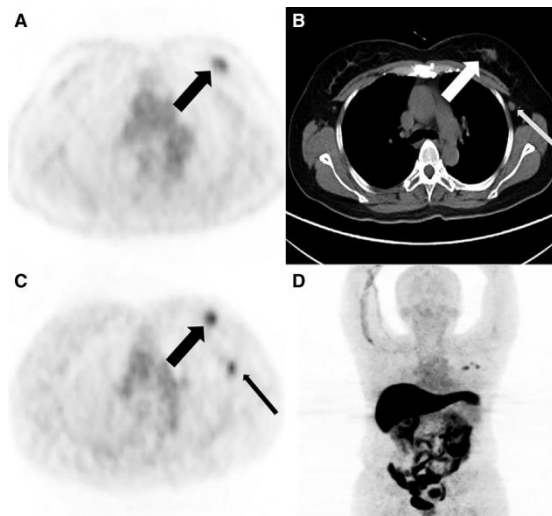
A 54-year-old woman with newly diagnosed ER-positive breast cancer. (A): Axial ^{18}F -FDG positron emission tomography (PET) show left breast mass uptake (black thick arrow). (B): Axial computed tomography (CT) shows a mass at the site of ^{18}F -FDG PET uptake, which is primary breast cancer (white thick arrow) and axillary lymph node (black thin arrow). (C): At the same level, ^{18}F -FES PET shows the mass (black thick arrow) and axillary lymph node (black thin arrow), considered to be estrogen receptor positive lesions. (D): ^{18}F -FES PET MIP demonstrates ^{18}F -FES avid focus in left breast mass and axillary lymph node. The left axillary lymph node contained metastases as proven by pathology after operation.
